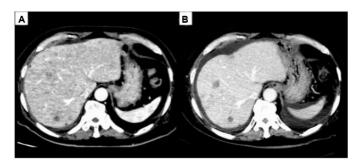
Assessment of liver metastases before and after wholeliver radiotherapy (WLRT). (A) Contrast-enhanced computed tomography (CT) image of the abdomen before WLRT showing diffuse liver metastases. (B) Contrast-enhanced CT image of the abdomen three months after WLRT shows the resolution of most liver metastases.
